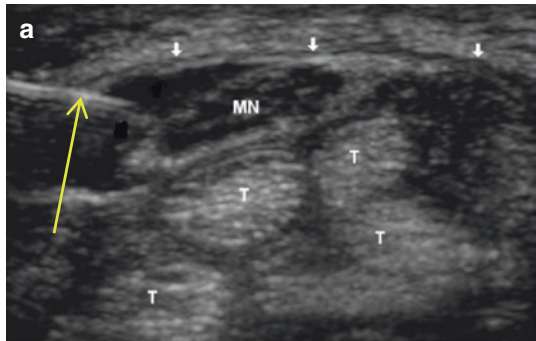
Ultrasound-guided CTS injection from ulnar (preferred) and radial side
